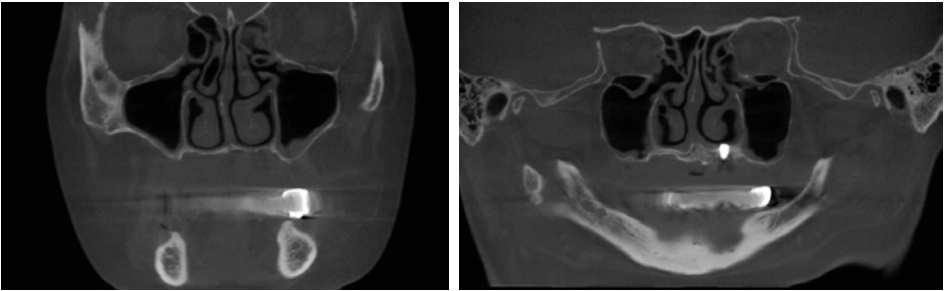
CT coronal view Fig. 2-2 CT panoramic view
